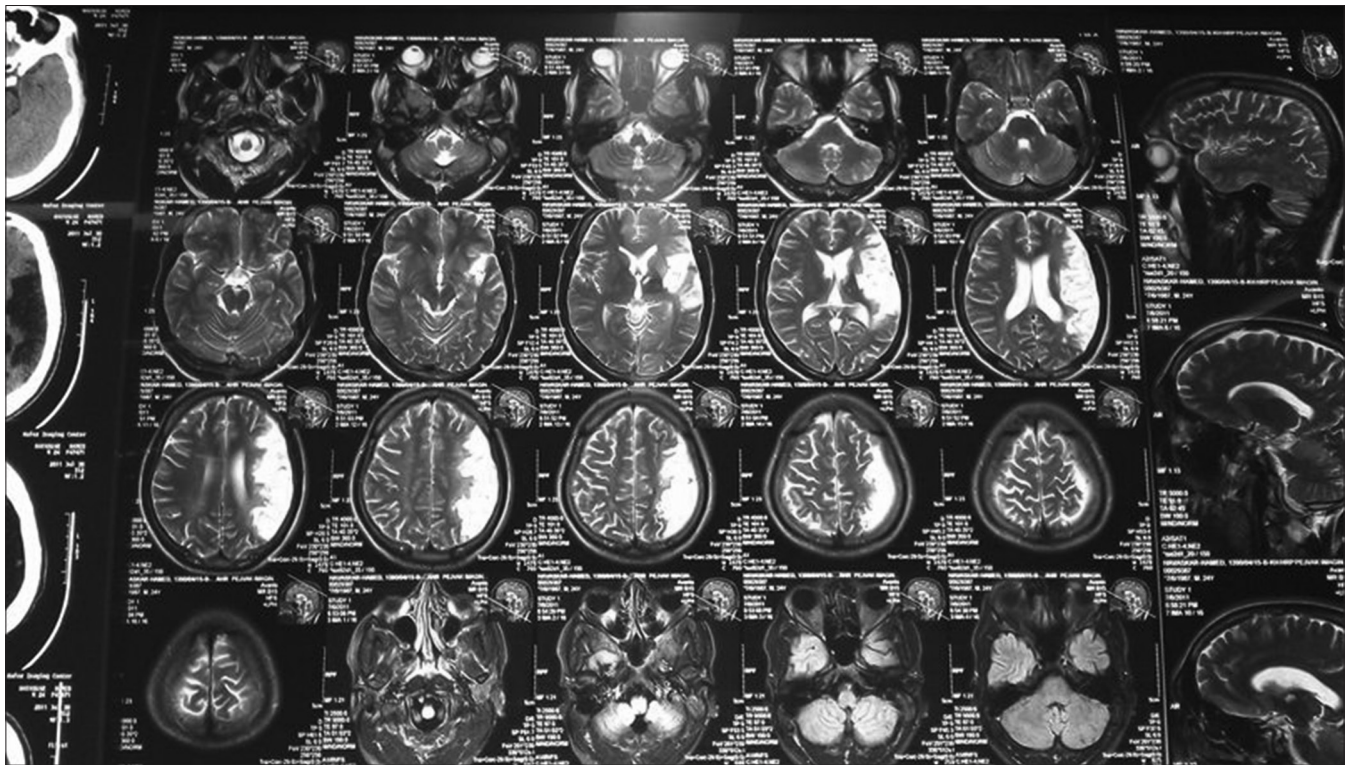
Patient's postoperation magnetic resonance imaging
